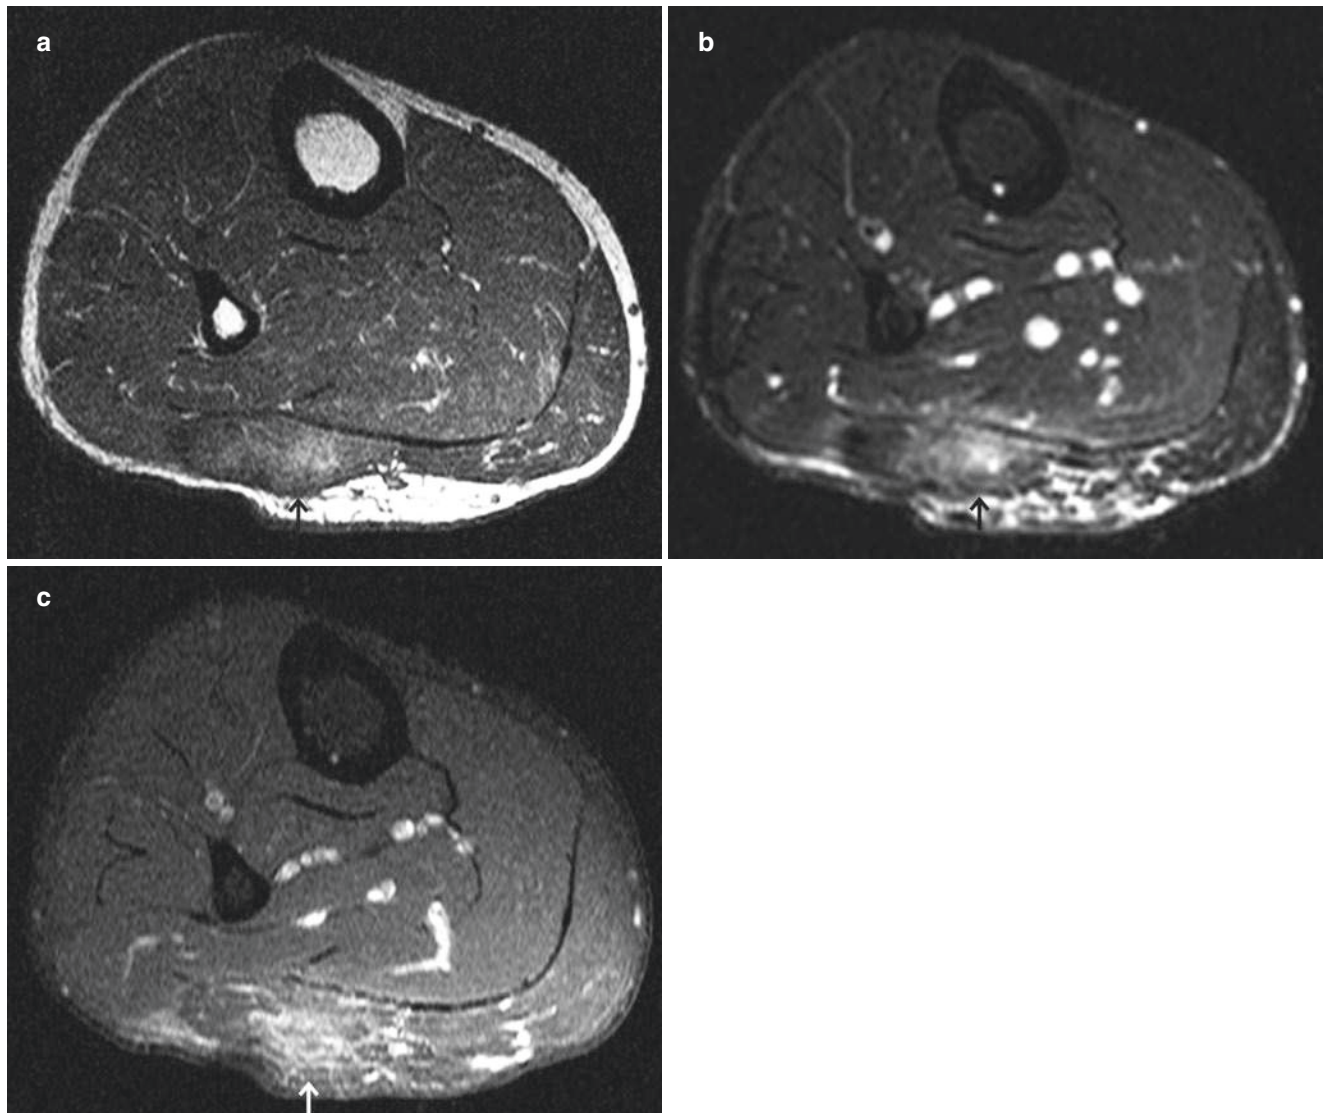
Typical appearances of diabetic muscle infarction (a) T1-weighted axial MR image of the calf showing T1 hyperintensity within lateral belly gastrocnemius muscle (*arrow*) as a result of intramuscular haemorrhage. (b) T2-weighted fat-suppressed axial images at
